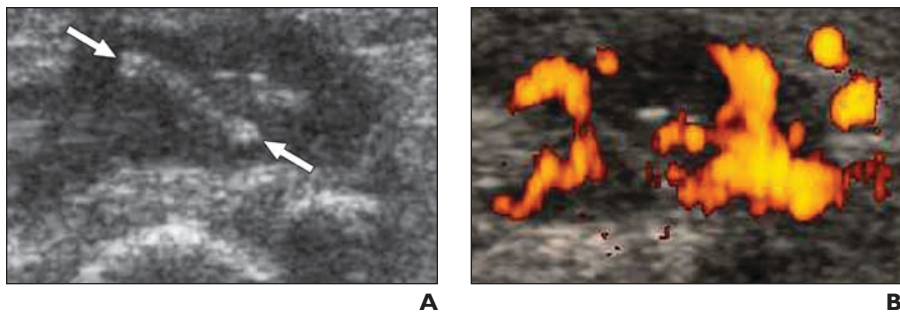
40-year-old woman who had persistent pain for 2 months after removing rose thorn from her finger after gardening. MRI showed flexor tenosynovitis, for which she was treated with nonsteroidal antiinflammatory medications, with little improvement.
